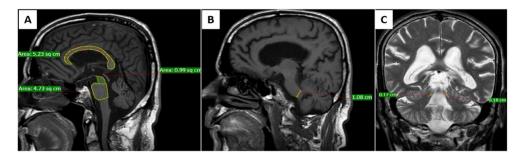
Sagittal T1-weighted MRI image of PSP showing the measurement of (A) corpus callosum area (5.23 cm^2), midbrain area (0.99 cm^2), pons area (4.73 cm^2), (B) MCP width (1.08 cm), (C) coronal T2-weighted MRI image of PSP showing the measurement of right SCP width (0.17 cm) and left SCP width (0.18 cm).
